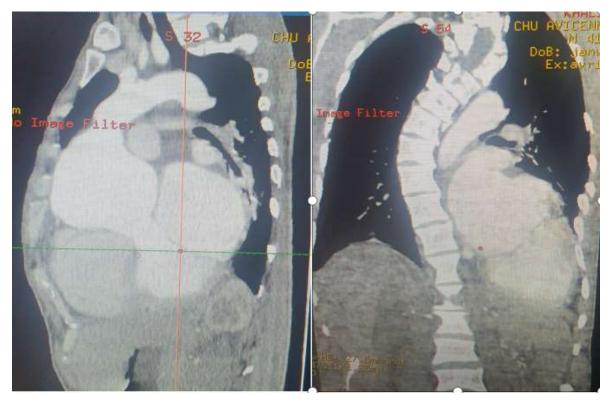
Aortic root dilatation seen in cardiac computed tomography (A), scoliosis (B)
